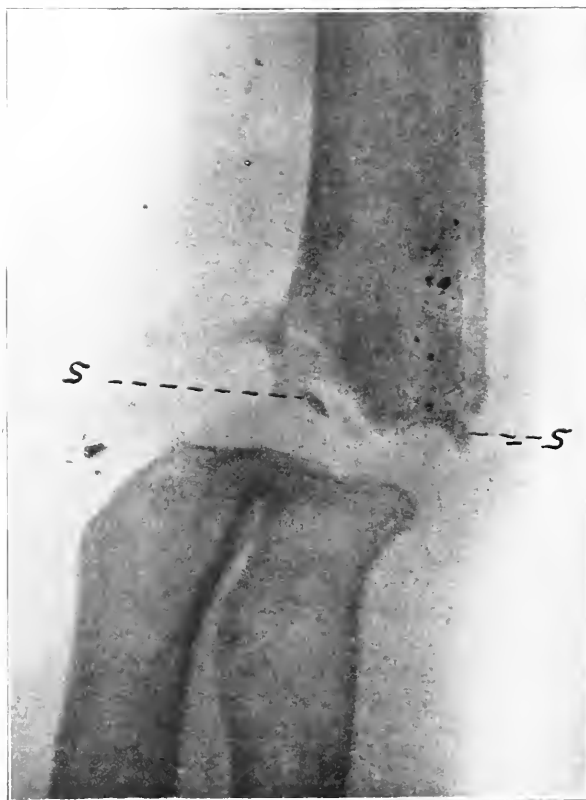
X-ray of an elbow joint, flail as the result of excision of comminuted fragments of bone soon after the occurrence of the wound. The wound healed in six weeks and never reopened, but an operation performed eighteen months later with a view to fixing the joint revealed the presence of two sequestra (*s, s*), each lying in a small pocket of granulation tissue. Cultures of the sequestra resulted in a pure growth of *staphylococcus aureus*. The operation upon the bones was postponed; the operation wound suppurated.
